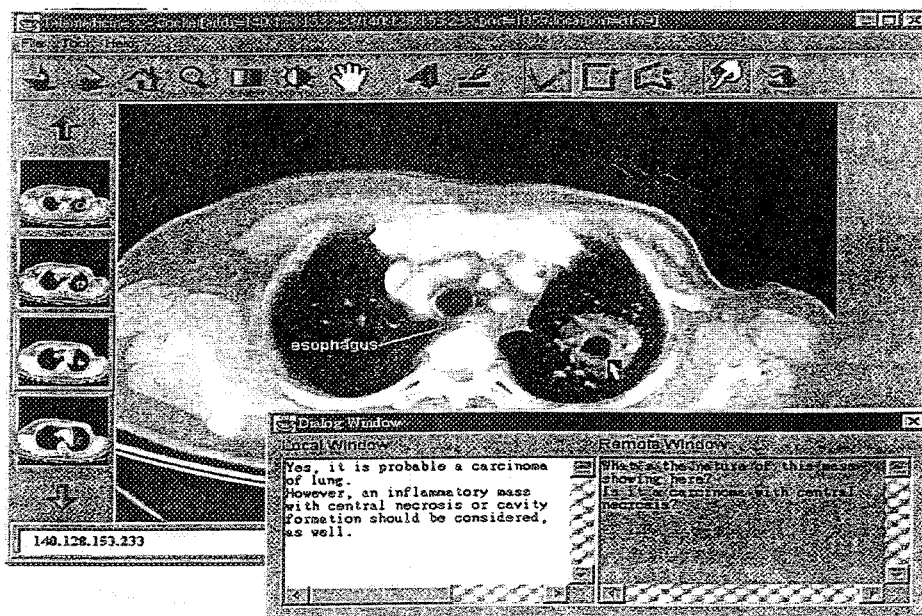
The interactive dialog box is presented on the coincided CT image during teleconsultation.
